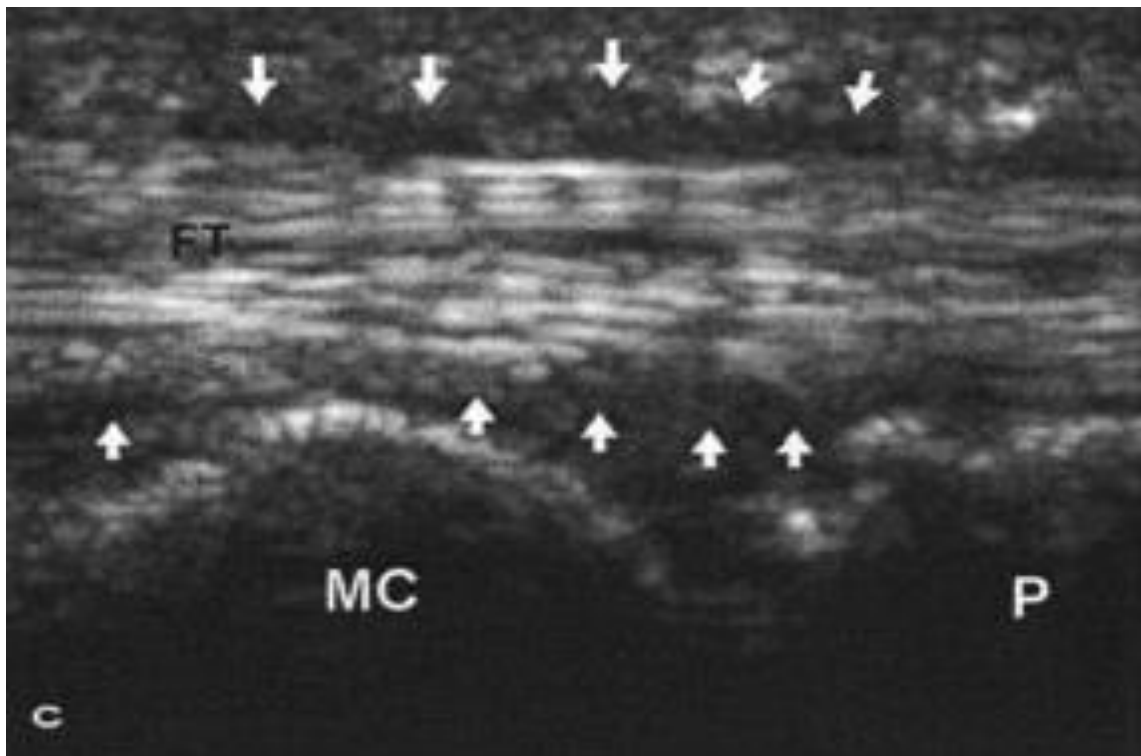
Edematous tendon with thickened A1 pulley and fibrotic Notta nodule visualized under ultrasound in longitudinal position.
